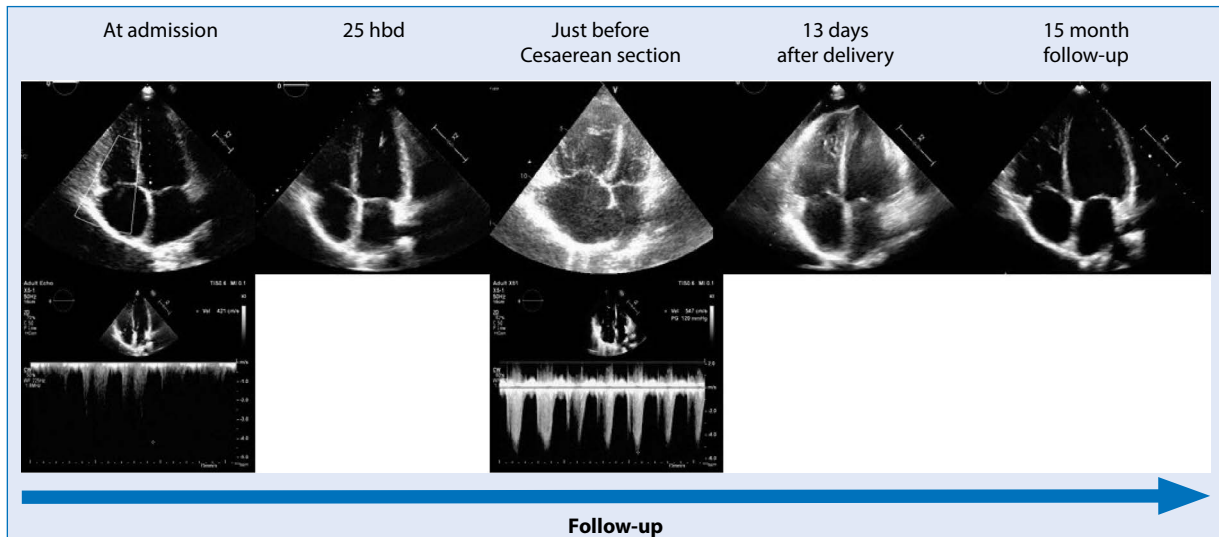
Transthoracic echocardiography — 4-Chamber views in different points of clinical follow-up
